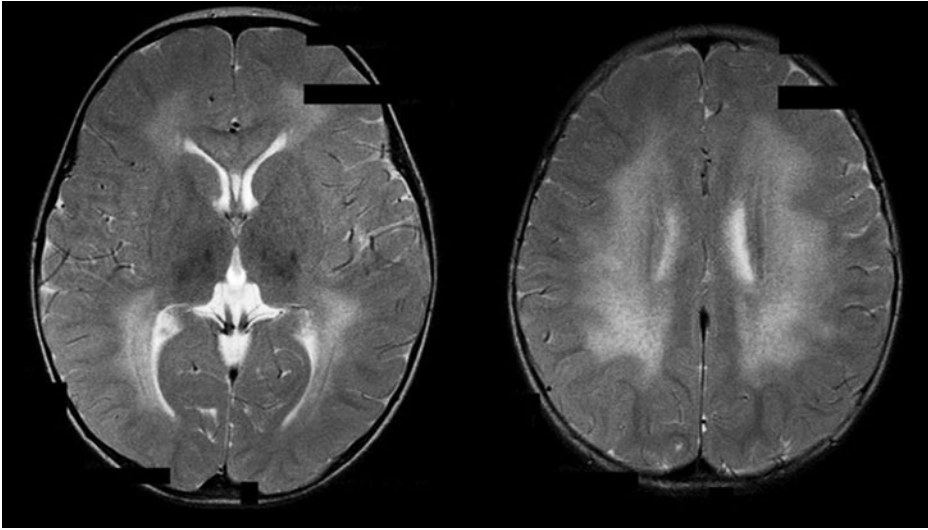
A 2-year, 10-month-old boy with the late-infantile form of metachromatic leukodystrophy. In this axial T2-weighted noncontrast MRI there are symmetric, confluent white matter abnormalities in all lobes that exhibit relative sparing of the subcortical U-fibers.
